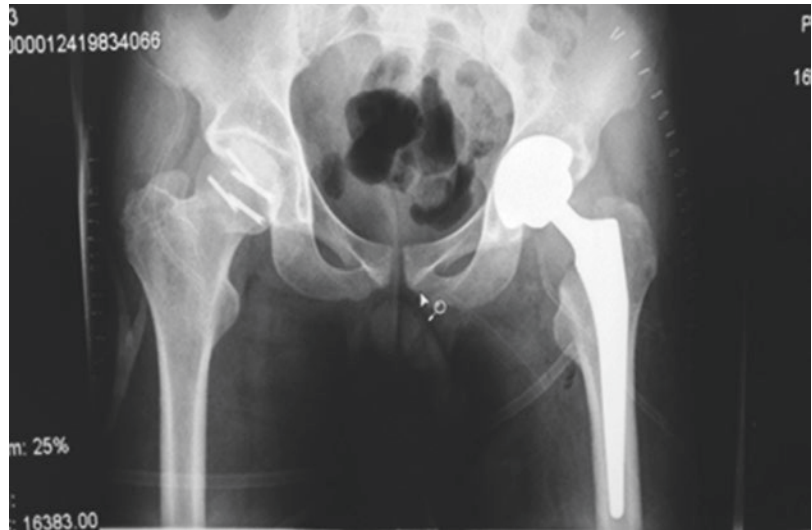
Shows a pre-oppelvis x-ray
